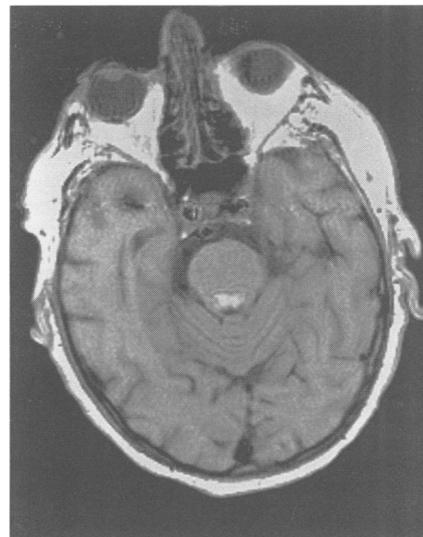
Increased signal on T1 weighted MRI (haematoma) in the pontine tegmentum.
